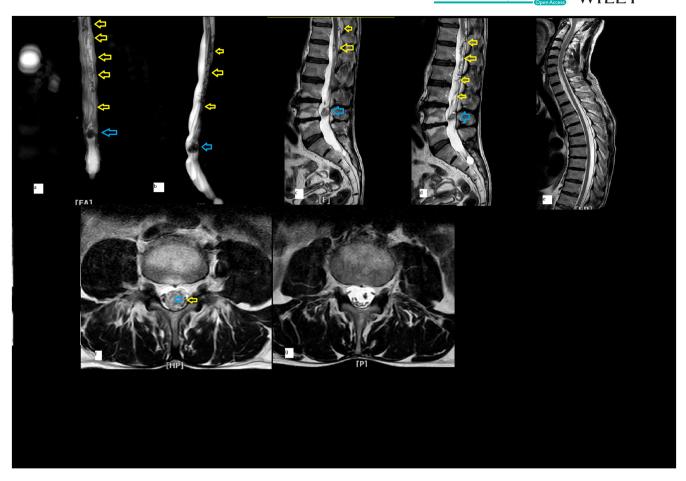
Preoperative MRI images show round-shaped intradural lesions posterior to L4 with multiple signal voids in the lumbar intrathecal space. (A, B) Anterior and lateral myelograms showing vascular tufts and round intradural lesions in the lumbar region. (C, D) Sagittal and parasagittal T2-weighted sequences demonstrating vascular malformation associated with a large intrathecal mass adjacent to L4 posterior surface. Cervicothoracic MRI (E) showed no other nervous system lesions. (F, G) Axial T2-weighted sequences showing the round vascular lesion had compressed roots dorsally. yellow arrow: vascular malformation, blue arrow: spinal aneurysm.
